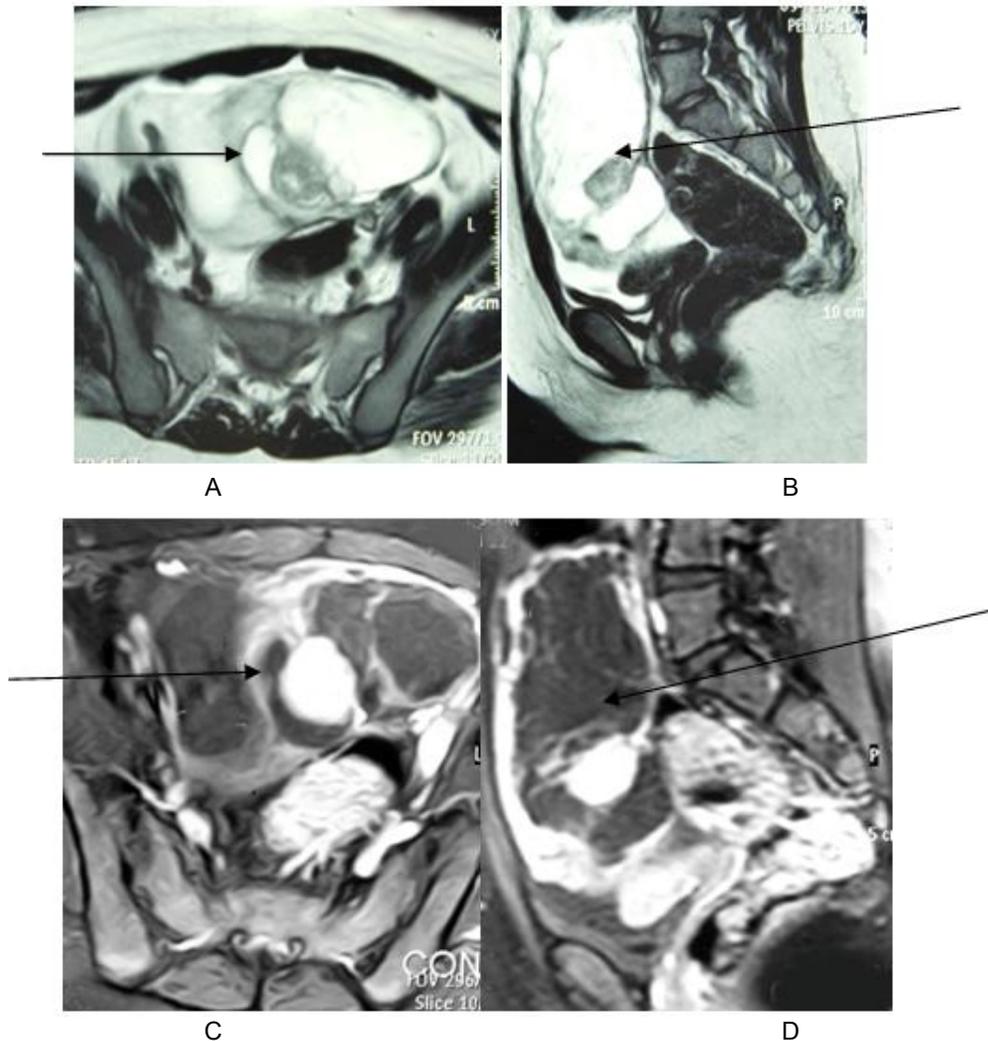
15-years-old female presented with abdominal pain and distension. Magnetic resonance imaging (MRI) of the abdomen was done. (A) Axial T2 and (B) Sagittal T2 weighted images revealed soft tissue mass(arrow) with multiple cystic components and central solid part. (C) Post-contrast axial T1 and (D) sagittal T1 with fat suppression revealed enhancement of the central solid part and septations. This mass was pathologically proved to be JSCT.
